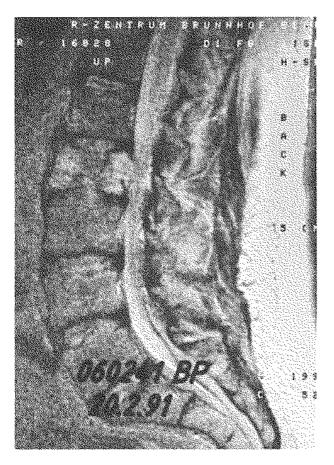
February 1991; MRI revealed tumor progression in the second lumbar body. Intralesional resection and Palacos implantation including dorsal stabilization of the second lumbar body was performed followed by radiation.
